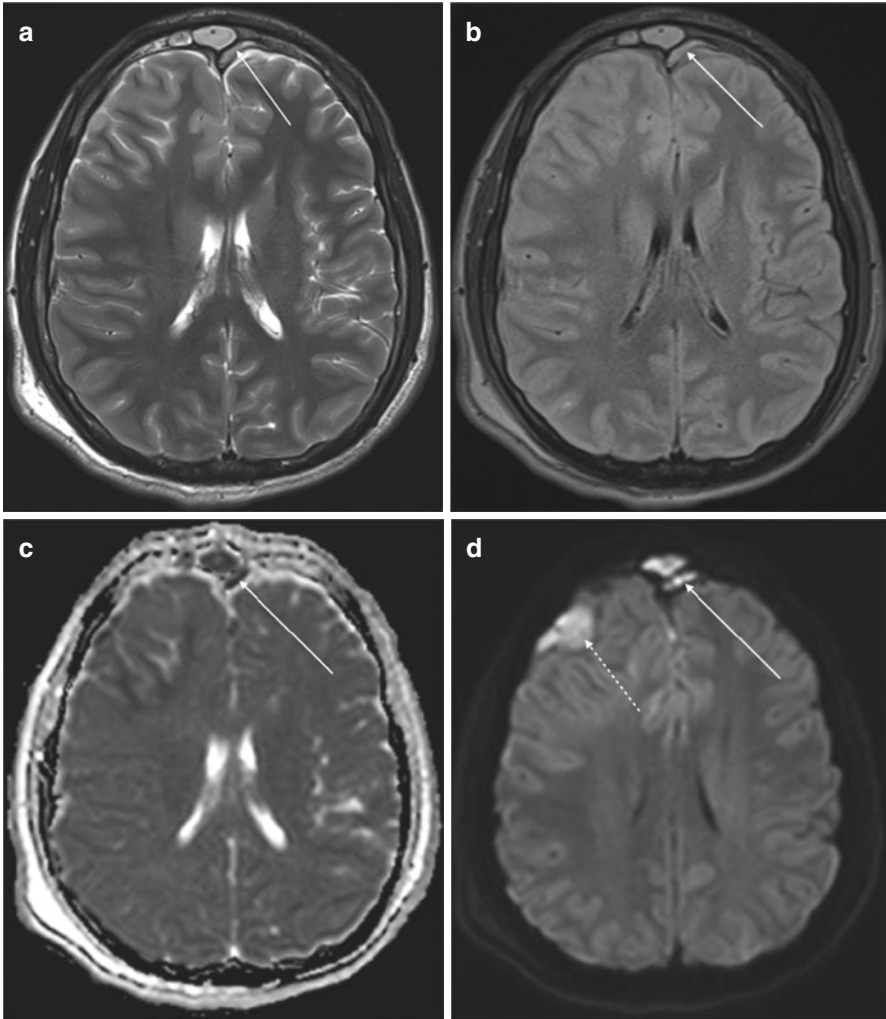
(a) Non-contrast MRI in a patient with an epidural abscess secondary to sinusitis. T2, Fluid Attenuated Inversion Recovery (FLAIR), Apparent Diffusion Coefficient (ADC) and Diffusion weight imaging (DWI) images in axial view showing evidence of signal abnormality in the left frontal epidural space beneath the frontal sinus, denoting an epidural abscess (solid arrows). There is also a focus of signal abnormality of the right frontal region on DWI denoting ischemic changes secondary to infection (broken arrow). (b) Non contrast MRI in a patient with post craniotomy epidural abscess. T2, Fluid Attenuated Inversion Recovery (FLAIR), and Diffusion weight imaging (DWI) images in axial view showing evidence of signal abnormality posterior to the left cerebellum (solid arrow). The collection does appear to have similar signal characteristics initially to CSF on the T2 image; however on FLAIR we can see that the collection is not CSF in density while on DWI, we can appreciate the collection is restricting, suggestive of purulent, hyper cellular material
